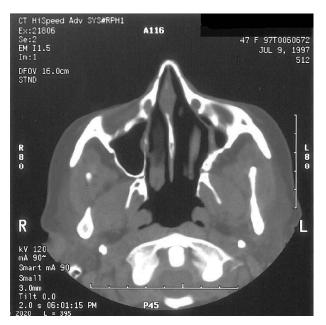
Axial CT scan showing left maxillary hypoplasia.
